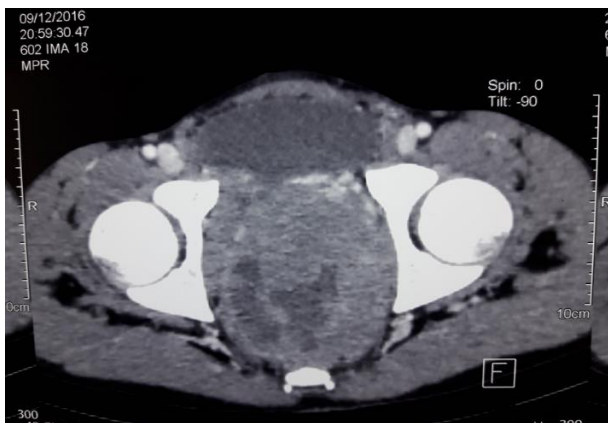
Bulky parietal tumoral process of the rectum, circumferential, II stenosis rectal lumen, heterogeneous tissue density enclosing hypodense areas of necrosis and calcifications to abdominopelvic computed tomography.
